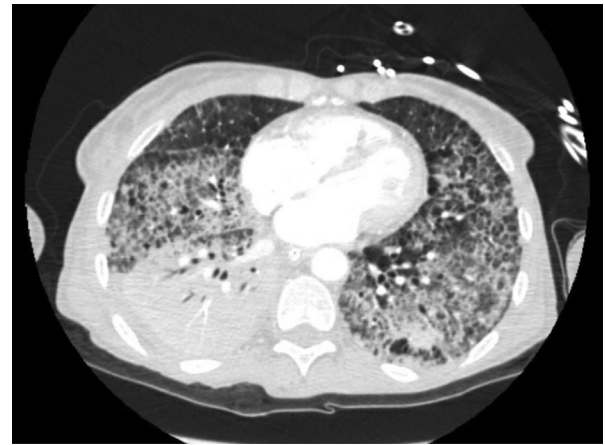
CT image of the lung bases showing the known right lower lobe lung mass and the diffuse ground glass opacities with septal thickening bilaterally.
